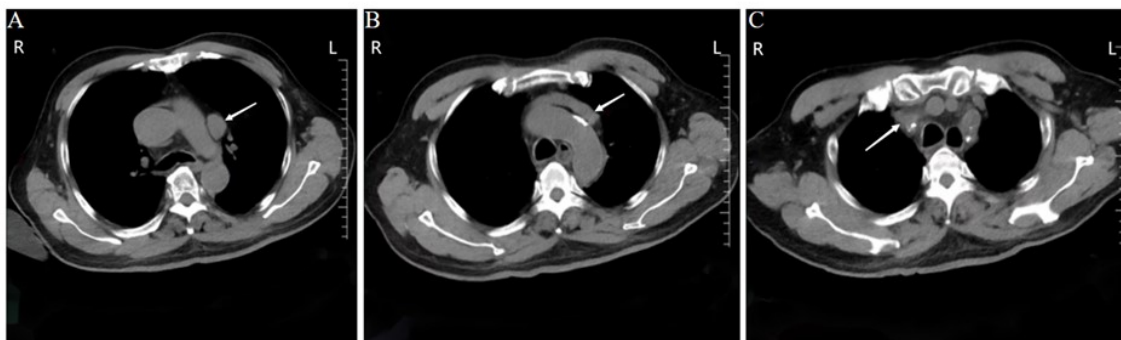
CT scan revealing a persistent left superior vena cava (LSVC). A: The confluence of the right subclavian vein and right jugular vein is visible on the right side of the brachiocephalic trunk (arrow), with no clear shadow of the right superior vena cava. B: A shadow of the superior vena cava is visible on the left side of the aortic arch (arrow). C: A shadow of the superior vena cava is seen on the left side of the main pulmonary artery and left pulmonary artery (arrow).
